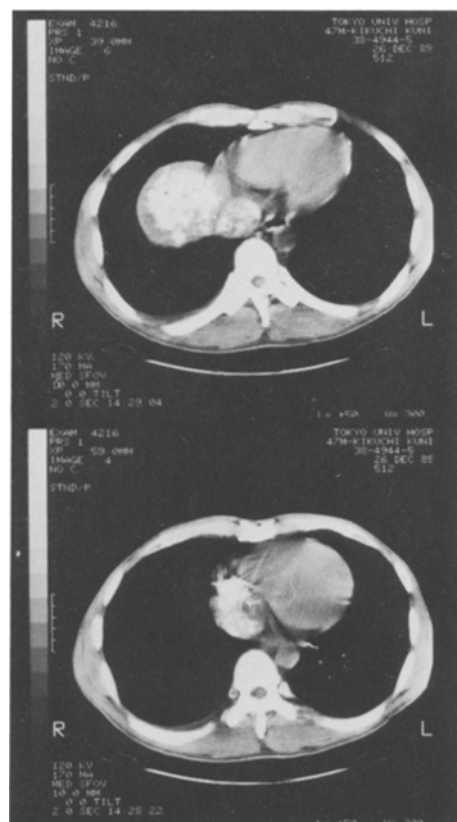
CT scan performed 5 days after the first TAE, demonstrating sufficient deposition of Lipiodol in the liver tumor (*upper panel*) and tumor thrombus (*lower panel*)
